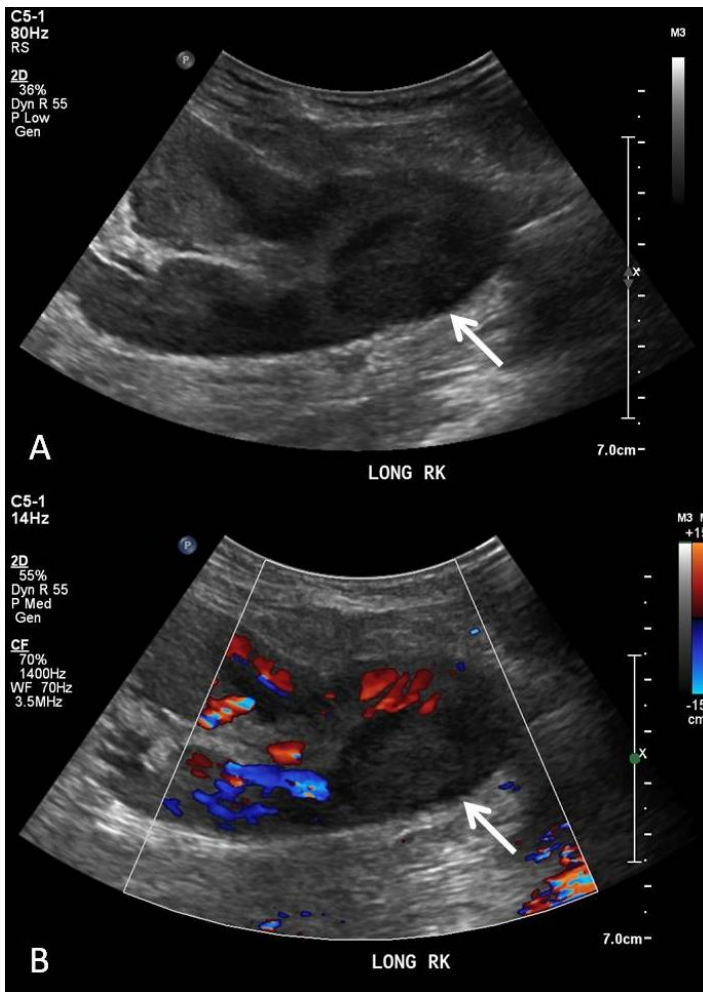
(left): Seventy-seven year-old man with post-transplant lymphoproliferative disorder. Findings: Longitudinal gray scale (A) and color Doppler (B) images demonstrate a solid, hypoechoic, hypovascular, cortically based mass (arrow) in the lower pole of the transplant kidney. Technique: Gray scale and color Doppler images of the right lower quadrant transplant kidney (Scanner: Phillips Epiq7®, curved probe, 1-5 MHz).
